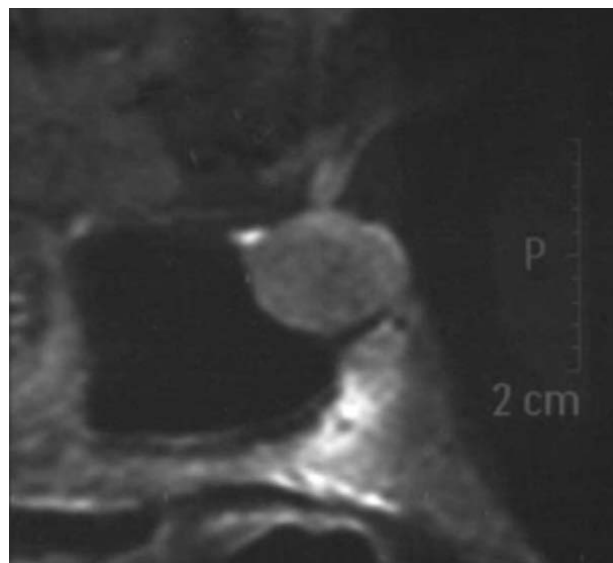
Sagittal section of sellar region on T1W MRI scan showing isointense pituitary adenoma measuring 15 × 13 × 10 mm
